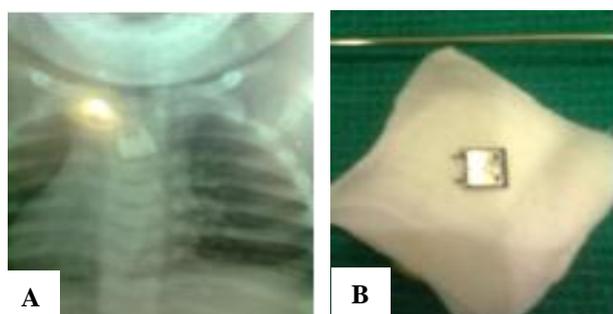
A= X-ray safety pin; B= Safety pin.
